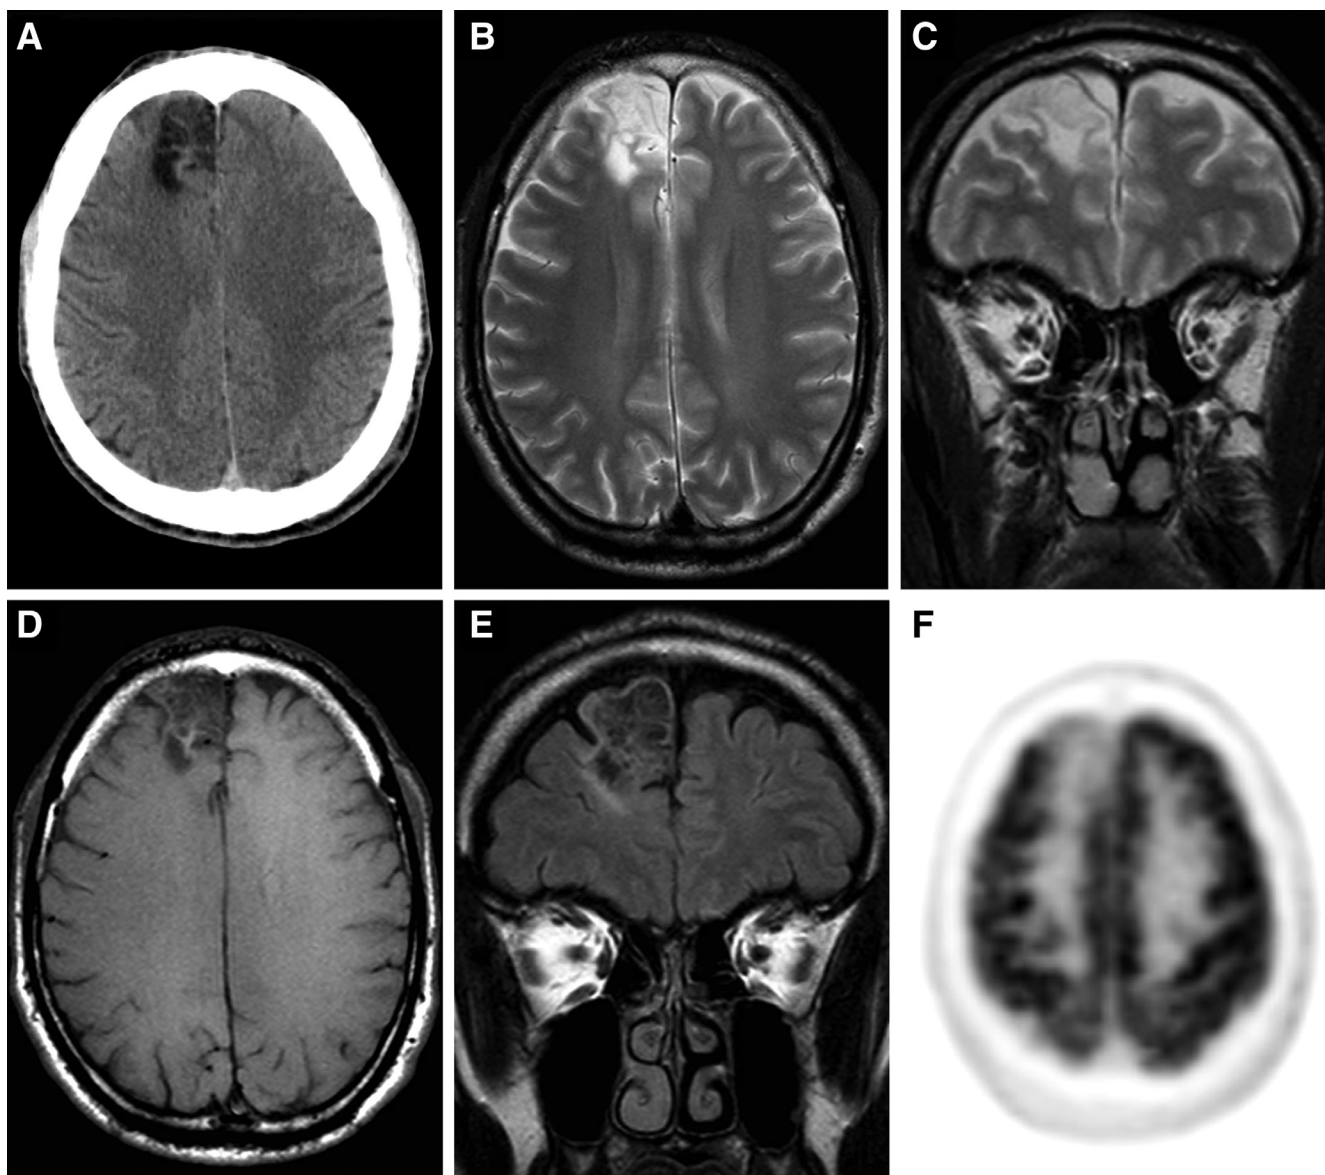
Axial noncontrast head CT (A; patient age 25 years) shows a hypoattenuating lesion in the right frontal lobe, involving the cortex and underlying white matter, with no appreciable mass effect, initially interpreted as encephalomalacia and gliosis. Axial (B) and coronal (C) T2-weighted images show that the right frontal lobe lesion has very hyperintense signal and involves the cortex and subcortical white matter. Axial T1-weighted image (D) shows that the lesion is predominantly hypointense but has subtle hyperintense signal at its periphery. The coronal FLAIR (E) image shows that the lesion has predominant hypointense FLAIR signal centrally but has a FLAIR hyperintense rim. (Images B-E, patient age 39 years) Axial PET (F; patient age 39 years) shows that the right frontal lesion is not FDG avid, a finding consistent with encephalomalacia.
